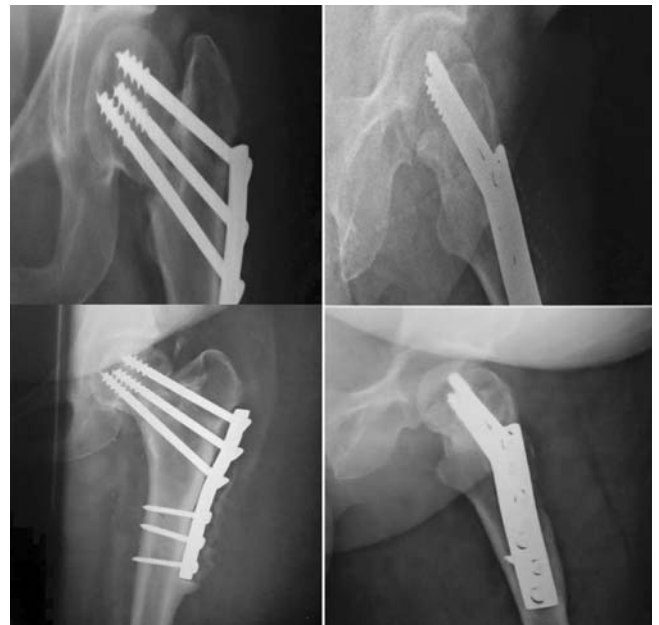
Post-Operative X-rays at one and two year follow up showing healing. Periosteal new bone is seen over plate due to low grade infection which cleared after removal of implant. This patient required removal of bone from inferior part of neck on femoral head side.
